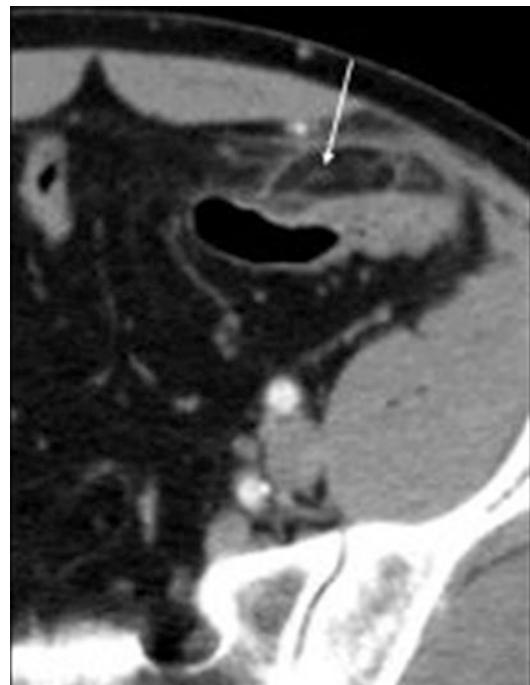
Epiploic appendagitis. Axial lower abdominal CT image with intravenous contrast shows an inflamed, oval-shaped focus of fat in the left lower quadrant anteriorly, with stranding stranding and a central area of vessel thrombosis (arrow), representing epiploic appendagitis in a 42-year-old patient. Note the lack of associated diverticulosis
